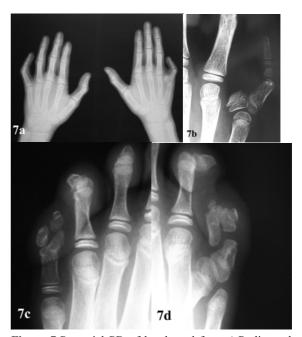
Postaxial PD of hands and feet. a).Radiograph shows clinodactyly of both little finger with incomplete MP duplication of fifth ray. b). The apperance of duplicated part in details. Note the epiphyseal longitudinal bracket associated with proximal delta phalanx and markedly hypolastic middle phalanx. c).Middle phalangeal duplication in left foot. Note the fusion of PIP joint. d). Radiology of right forefoot. Fifth ray duplication of the hypolastic metatarsal like the case in figure 3b.
